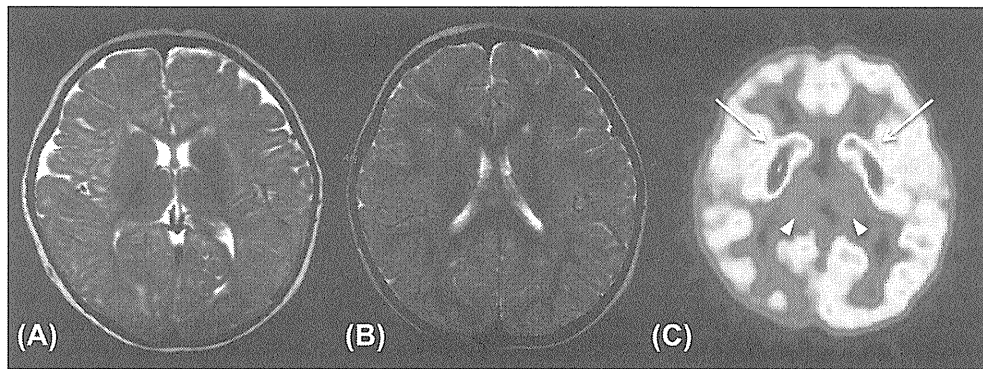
MRI and FDG-PET (fludeoxyglucose-positron emission tomography) findings of a patient with GLUT-1 DS. (A) T2-weighted image at 12 months of age shows high intense signal in the widespread subcortical and deep white matters, suggesting delayed myelination. (B) T2-weighted image at 2 years and 9 months of age shows multiple subcortical high intense areas. (C) FDG-PET at 3 years and 4 months of age revealed relatively enhanced accumulation of glucose in the bilateral basal ganglia (white arrows) and hypometabolism in the bilateral thalami (white arrow heads). The right occipital lobe is also hypometabolic.
